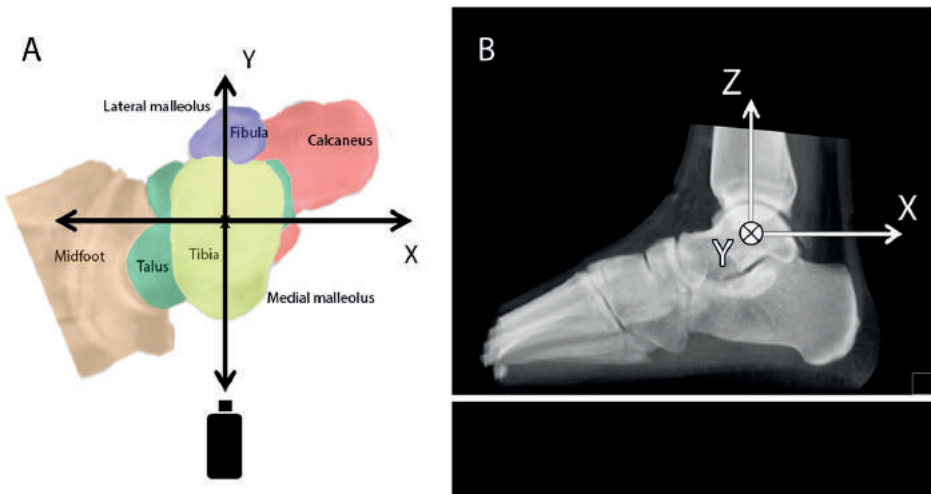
A. Top view of an ankle and coordinate system. B. A digitally reconstructed radiographic (DRR) image representing a Standard Lateral View. In this view the coordinate system is defined.
